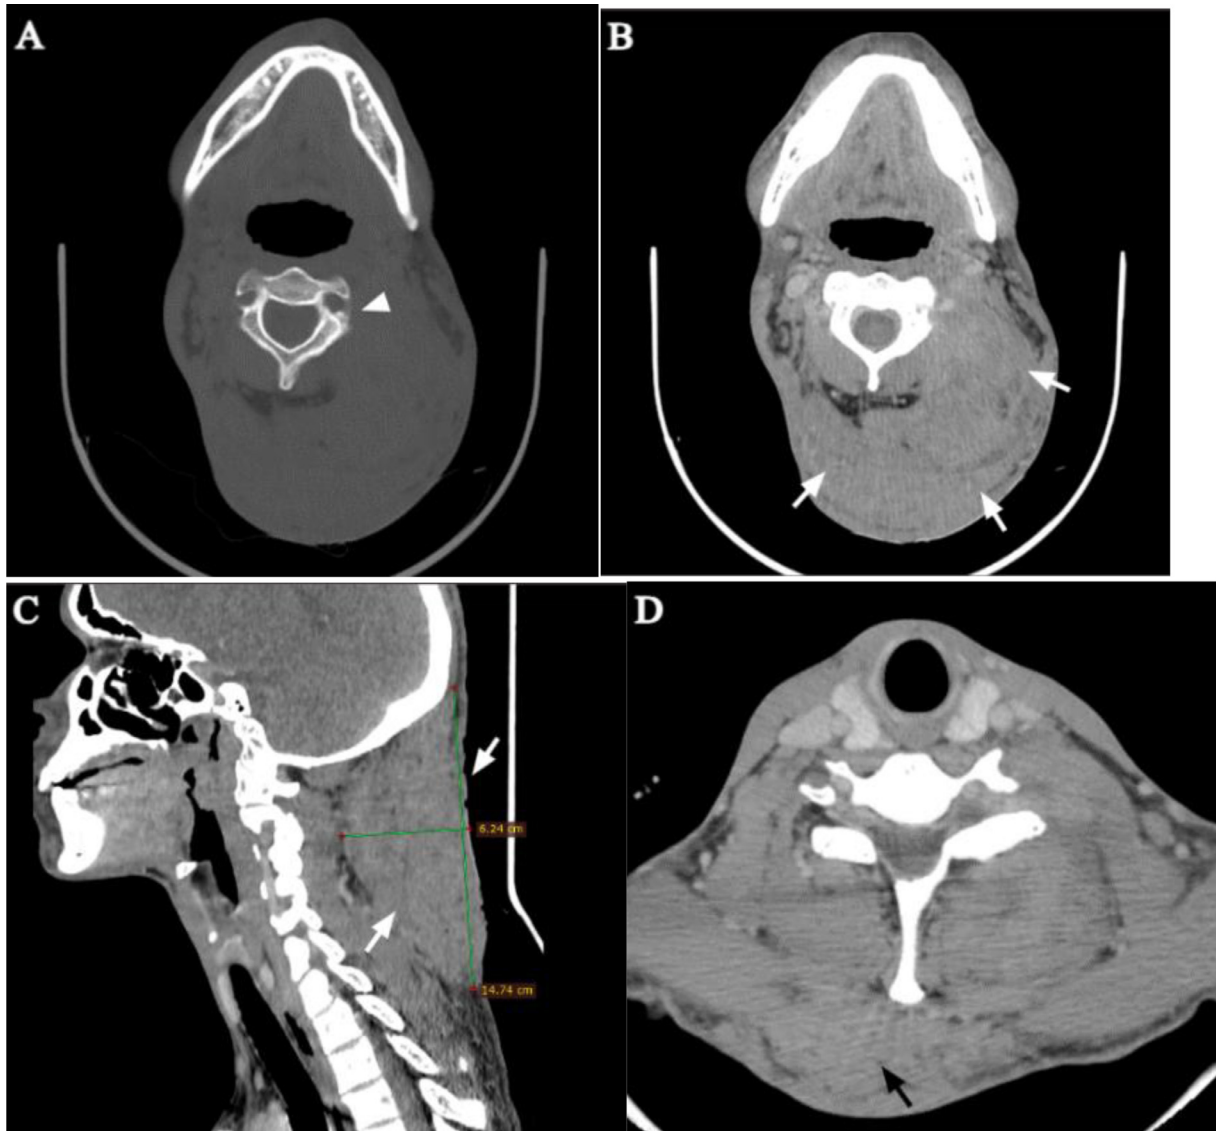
Cervical CT with axial pre-contrast (A) and post-contrast (B) views at C2 level, post-contrast left parasagittal view (C), and post-contrast axial view at C7 level (D) - There was a large, 14.7 x 6.3 cm (white arrows in B and C) longitudinally oriented, predominantly left posterior cervical soft tissue swelling that crossed the midline. It spanned from the suboccipital to the cervicothoracic vertebral junction level. The lesion diffusely infiltrated through tissue planes to involve the perivertebral muscles and the left posterior cervical space. More inferiorly, the proximal right trapezium muscle was involved (black arrow in D). Significant surrounding fat stranding as well as skin infiltration were noted. The lesion isoenhanced to adjacent muscles. On precontrast CT, there was non-specific periostitis of the left C2 lamina only (white arrow head in A). Intralesional calcification was not present. No significant cervical lymphadenopathy.
